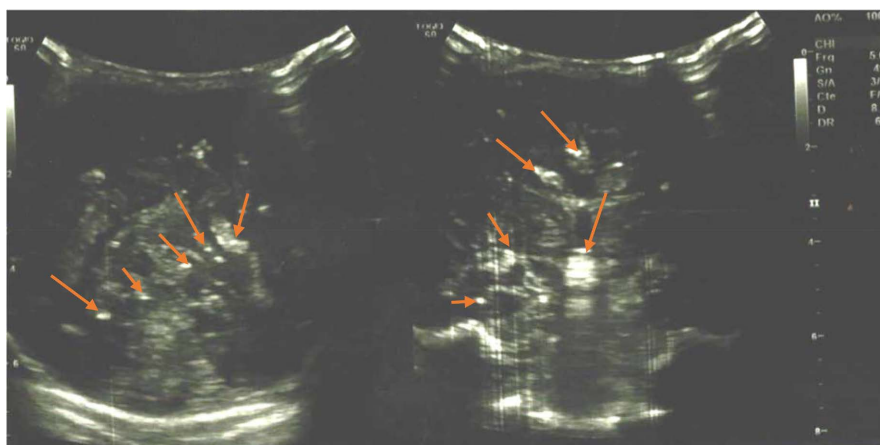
Transfontanellar ultrasound of SB revealing intraparenchymal calcifications.
